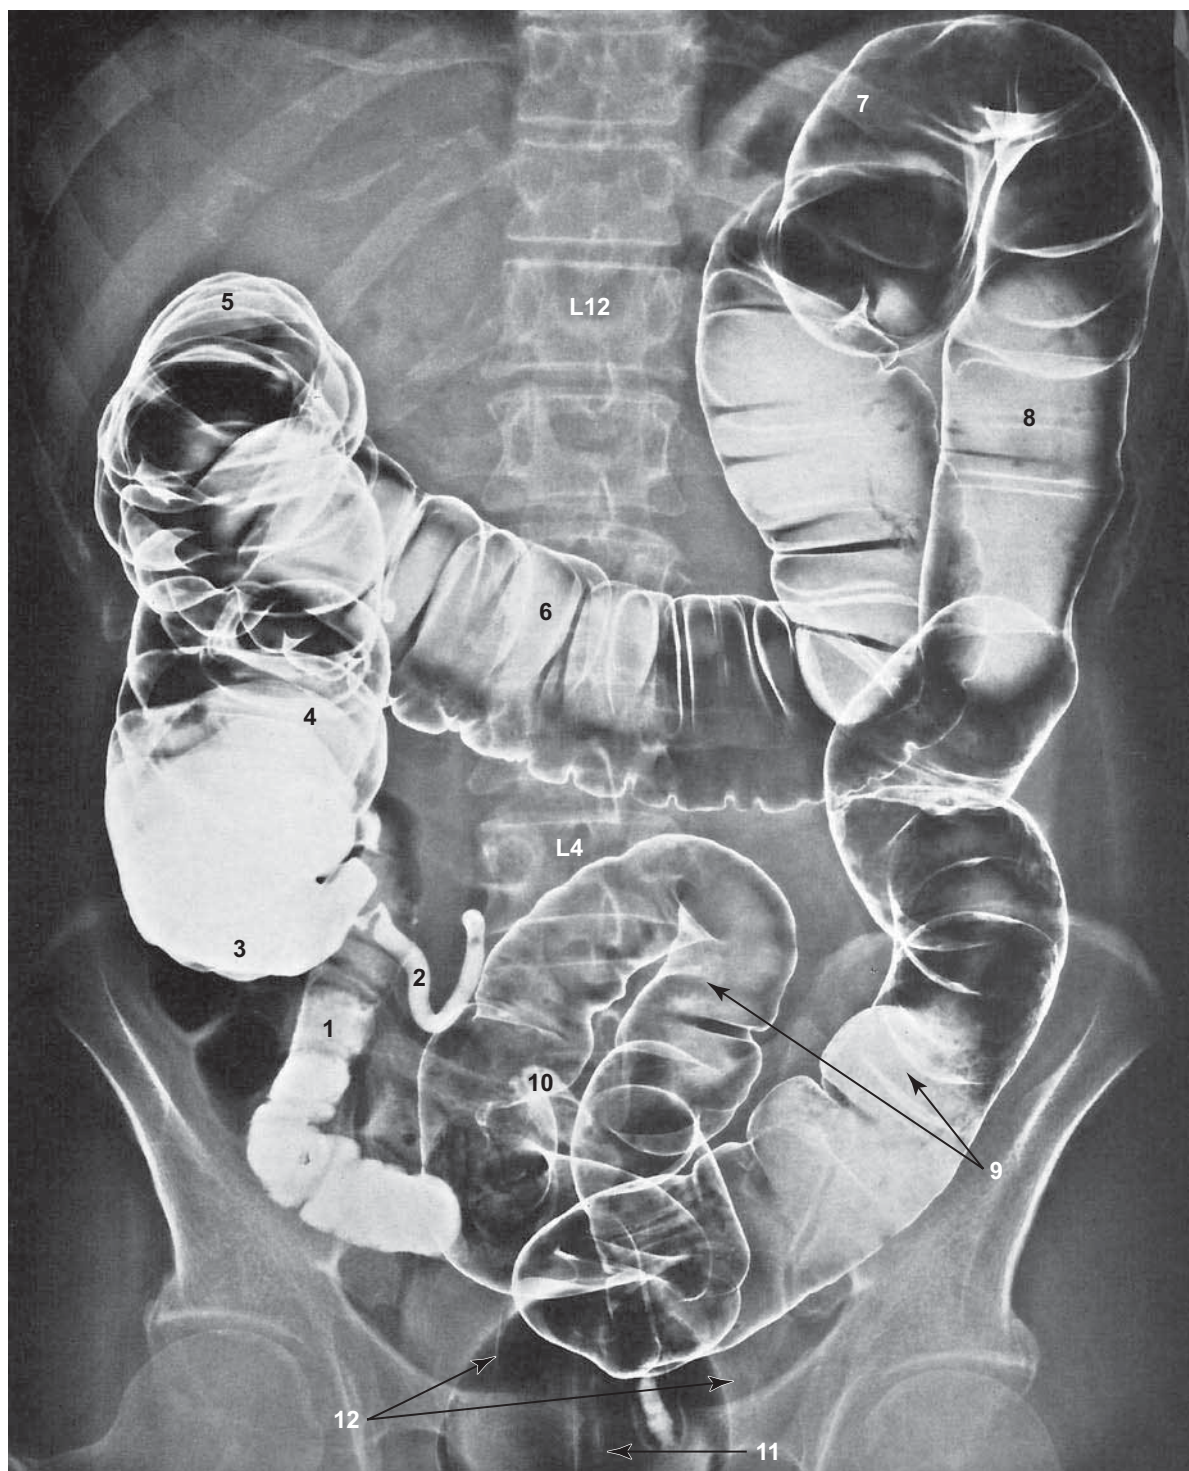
Radiographic Anatomy of the Large Intestine (Double Contrast)
